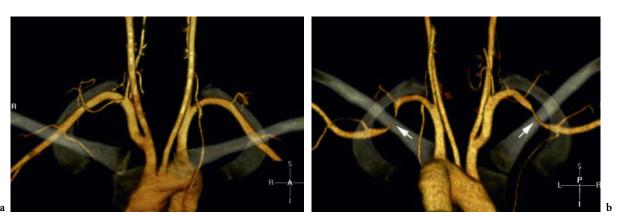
Bilateral thoracic outlet syndrome explored with CT imaging with the arms alongside the body (a) and after elevation of the arms (b). Compression of the subclavian artery in the entrance of the costoclavicular space (*arrows*) is well demonstrated after elevation of the arms
